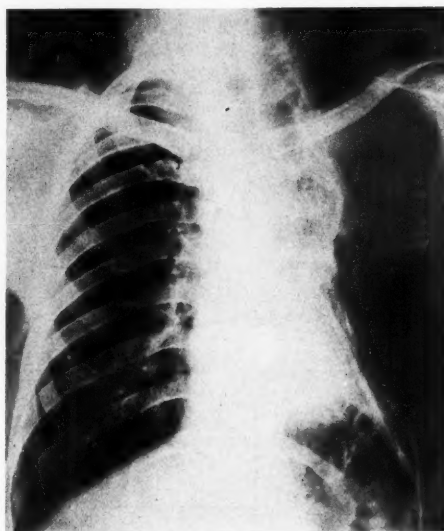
An example of the use of the plate divider in which the left lung was radiographed with a penetration of 14 K.V. higher than the right. Note the difference in shoulder and neck shadows and the absence of any line of division.
